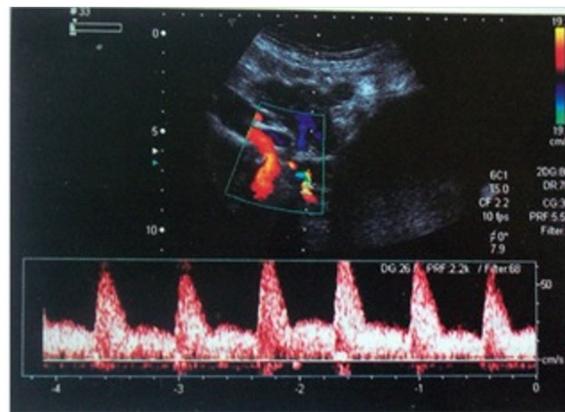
Abnormal color Doppler wave form of the uterine artery demonstrating low diastolic flow and an early diastolic notch.
